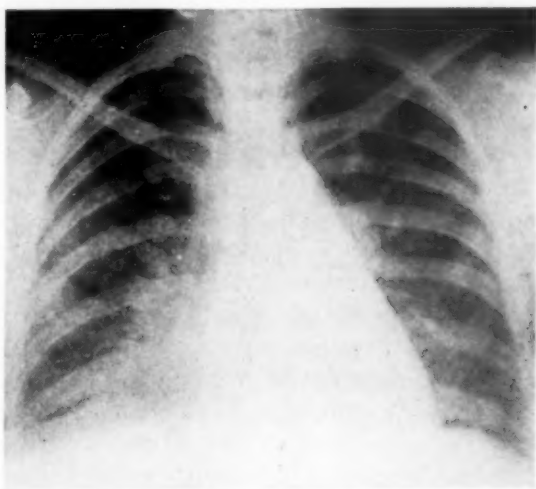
Roentgenogram showing cardiac silhouette characteristic of cor pulmonale. Bulge in the region of the cardiac waist ("filling" of waist) is due to dilatation of pulmonary artery and conus.
